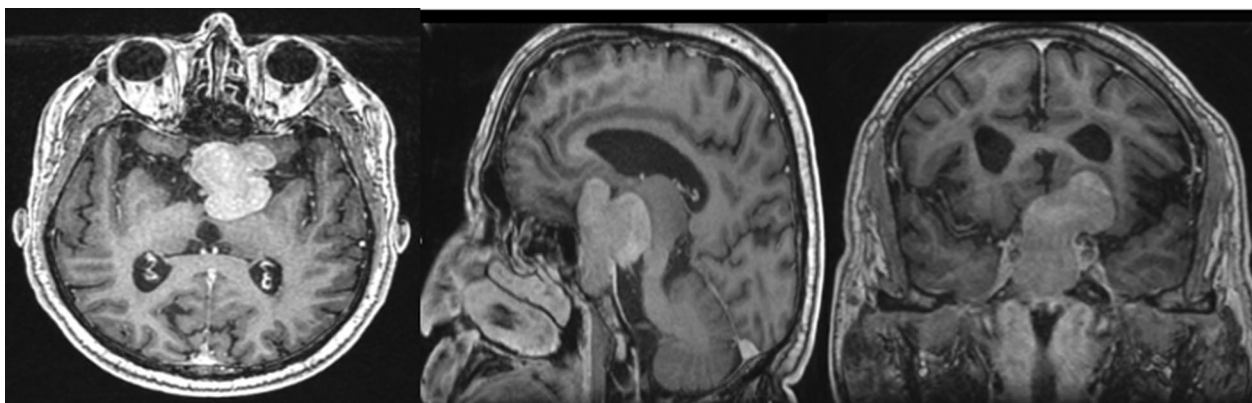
A T1-weighted axial, sagittal, and coronal gadolinium-enhanced MRI scan of the brain shows a giant pituitary mass with large suprasellar and parasellar components
